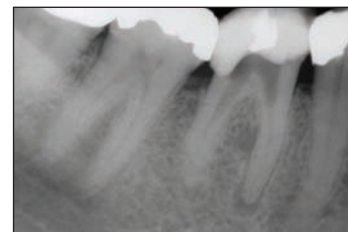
Molar with periapical areas and mid-root lucency at the distal surface of the mesial root. Patient was referred due to blockages in mesial and distal canals.
